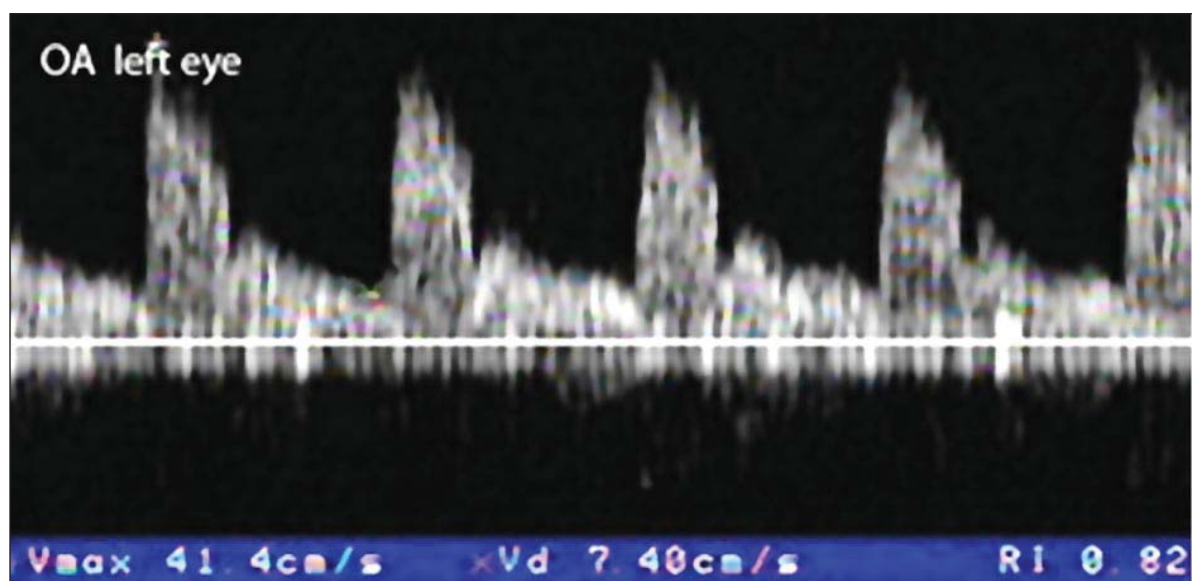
a, Patient TL-Spectral Doppler analysis of ophthalmic arteries (OA).
